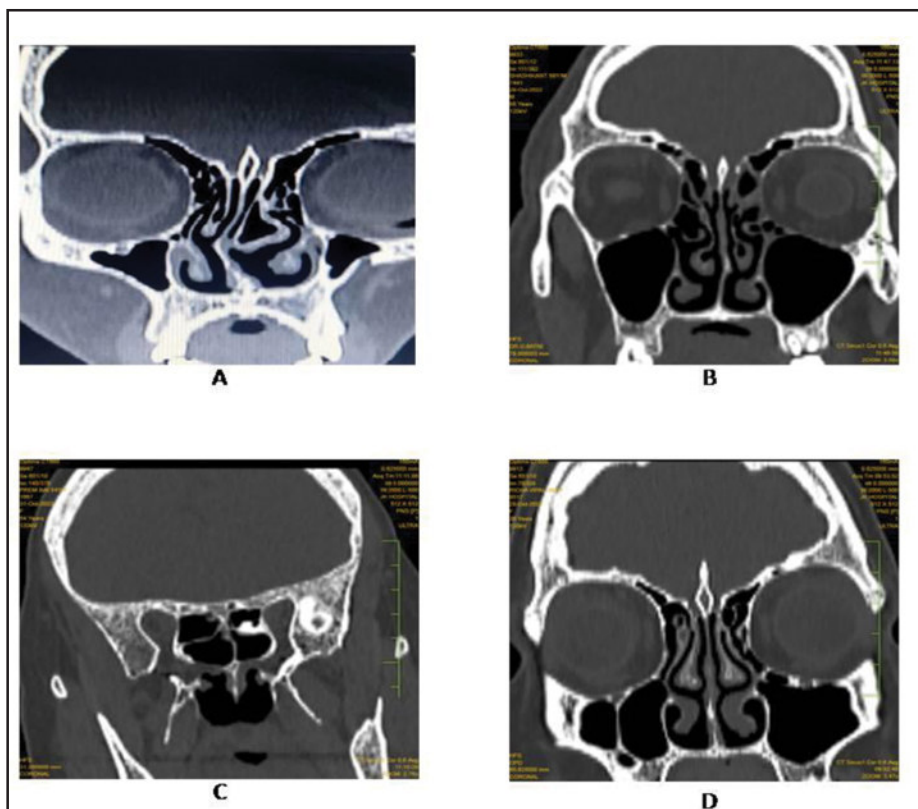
A. CT scan showing left septal spur with Concha Bullosa
